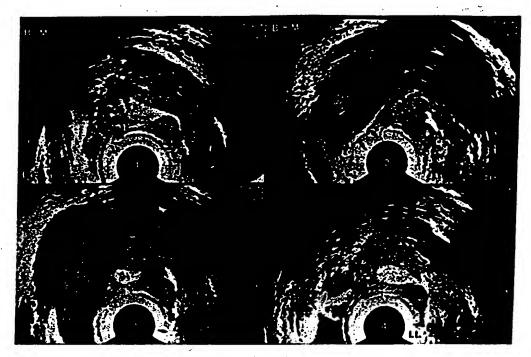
Transvaginal hysterosalpingo-contrast-sonography using SH U 454 through the cervical canal. (1) Longitudinal section of the uterus (U) filled with SH U 454; (2) Lumen of right tube (RT) perfused (arrow), cross-section of fundus uteri (arrowhead); (3) Lumen of left tube perfused (arrows), cross section of fundus uteri; (4) Transfer of contrast medium from cavum uteri (cross-section) to the pars intramularis of left tube (LT). (From Deichert U, Schlief R, van de Sandt M, et al., with permission.)
